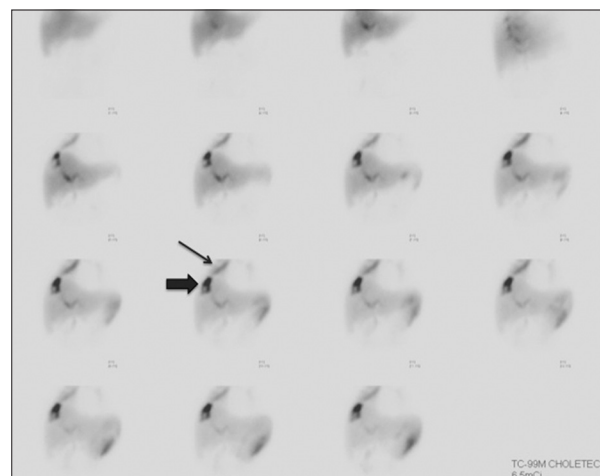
Planar cholescintigraphy with technetium-99m mebrofenin performed 1 day after the onset of biliptysis. Images were acquired over 60 min. Radiotracer collects in the site of the hepatic abscess (thick arrow) and then extends via the fistula into the right lung (thin arrow). There is also appearance of radiotracer in the left upper abdomen likely related to bile leak
